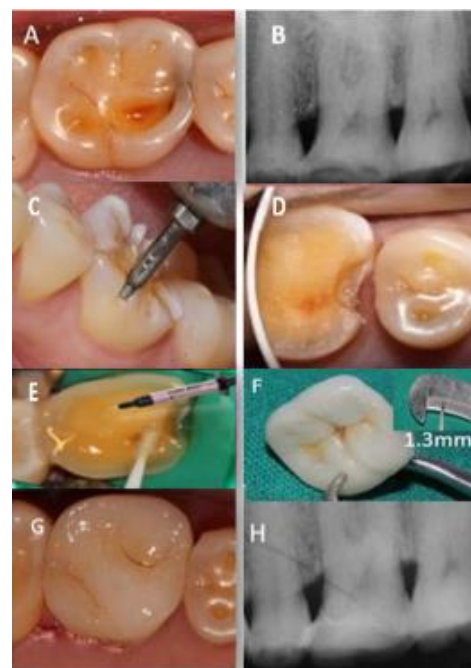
A: Pre-operative photographs; B: Pre-operative radiograph; C: Occlusal depth cuts D: Caries excavation followed by tooth preparation; E: Selective etching & Immediate Dentinal Sealing; F: 1.3mm thin CAD fabricated EMAX lithium disilicate occlusal veneer; G,H: Post-operative results with 18 months of Follow-up.
